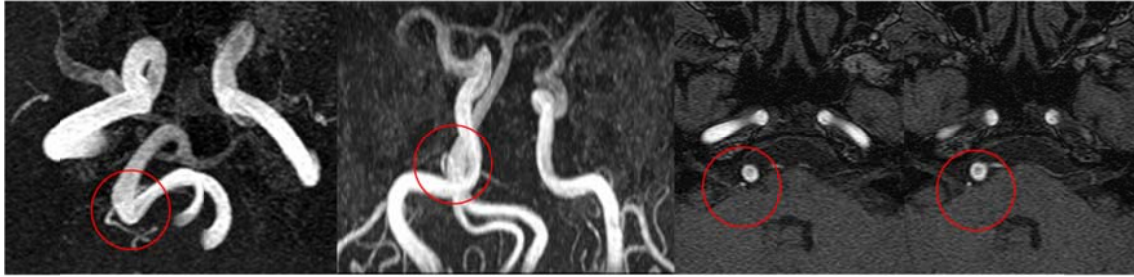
Preoperative MRI of a patient with AICA offender and BA over AICA. The patient was 48 year old man with right side facial spasm for 2 years. Preoperative MRI showed that AICA compressed facial nerve and BA was over AICA offender (*red circle*) at the REZ. During MVD, we made an effort to make BA move freely. After surgery, HFS completely resolved but transient facial palsy occurred.
